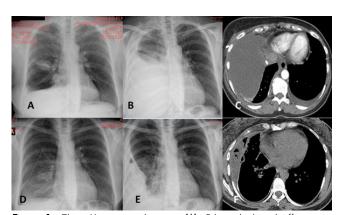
Chest X-ray on admission (A), Bilateral pleural effusion on Chest X-ray (B), Bilateral pleural effusion on CTT (C), Regression of primary lesion after effusion drainage (D), Complete response of pleural effusion on the left side and organized effusion on the right side (E), Regression of pleural effusion on CTT (F)
